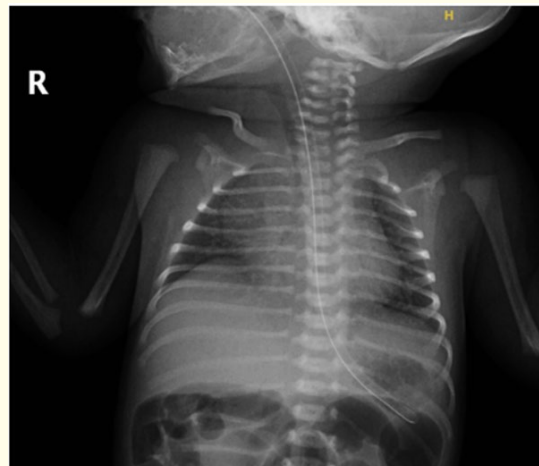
Chest X-ray. Hypoplastic right first rib.
